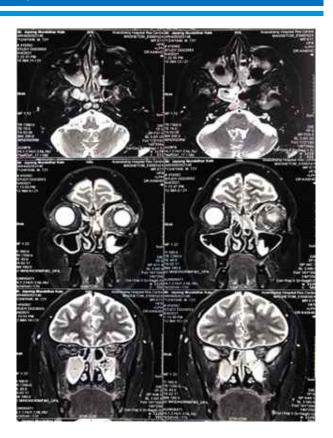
Pre-operative MRI Scan showing involvement of Paranasal sinuses & Left Orbit
